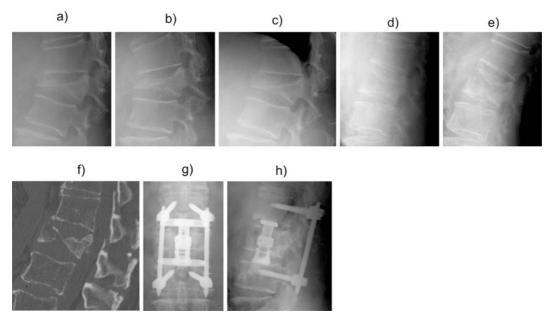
A 74-year-old man with a fracture of the 2^{nd} lumbar vertebral body. Preoperative lateral radiograph: Kyphotic angles of 35° in the flexion position (a), 32° in the intermediate position (b), 24° in the extension position (c), 0° in the supine position (d), -5° in rollback (e); preoperative sagittal computed tomography scan (f) and postoperative frontal (g) and lateral radiographs (h), kyphotic angle of 0° .
